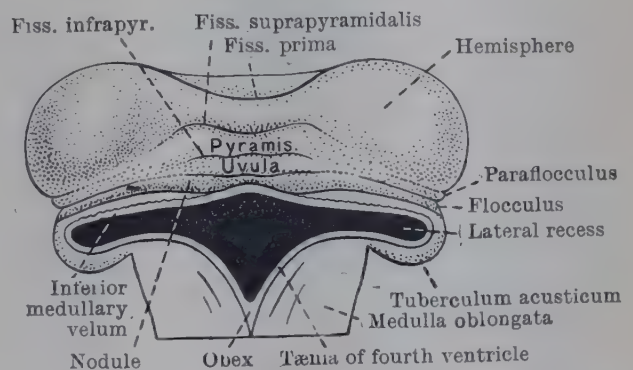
DORSAL ASPECT OF FETAL (FOURTH MONTH) CEREBELLUM, MEDULLA OBLONGATA AND FOURTH VENTRICLE.
